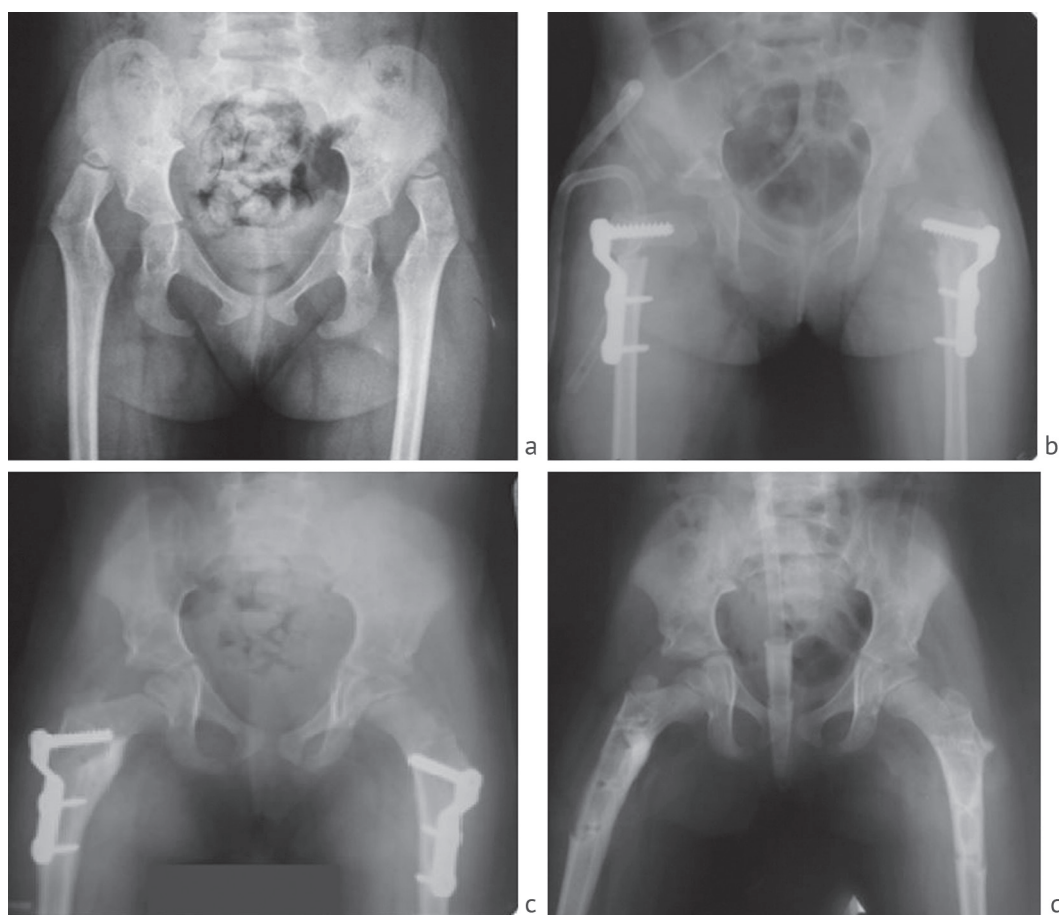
Bilateral VDO + acetabuloplasty according to San Diego with a short interval between operations (3 weeks). Patient B., 6 years old, GMFCS level IV. AP Radiographs of the pelvis: a before surgery: Reimers index 100 % on the right and left; AI 35° on the right and left; ADI 2.5 on the right, 3.6 on the left; b after surgery: Reimers index 0 %; AI 18° on the right, 17° on the left; ADI 4.2 on both sides; Wiberg angle of 27° on the right, 25° on the left; c one year after the operation: Reimers index 0 % on both sides; AI 13° on the right, 18° on the left; ADI 3.8 on the right, 3.9 on the left; Wiberg angle of 37° on the right, 35° on the left; d two years after the operation: Reimers index 0 % on both sides; AI 15° on the right, 16° on the left; ADI 3.4 on the right, 3.8 on the left; Wiberg angle 36° on the right, 35° on the left
